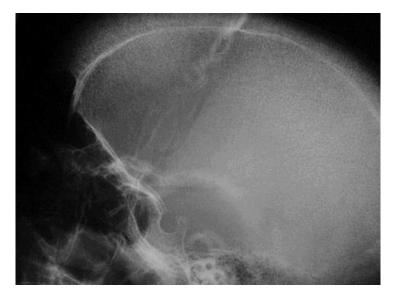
Skull X-ray Demonstrating "Hair on End" Appearance of Thalassemia
